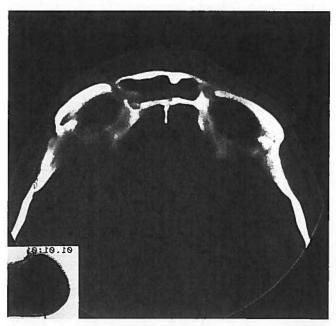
Axial CT-scan showing fluid level in the frontal sinus. Soft tissue swelling (Pott's puffy tumour) is visible anterior to the anterior table.
